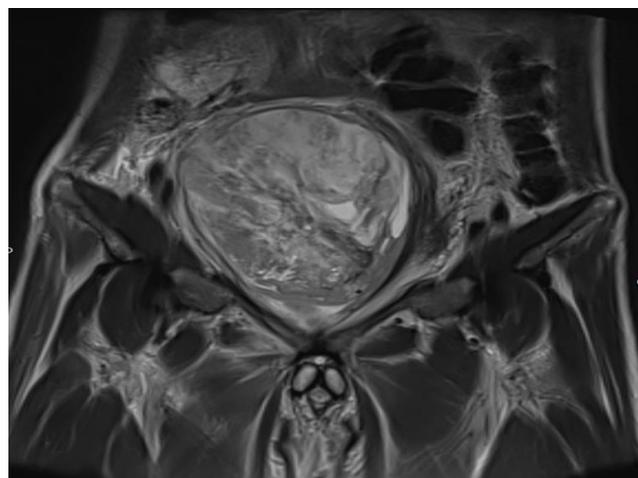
a) Pelvic MRI: T2 coronal
